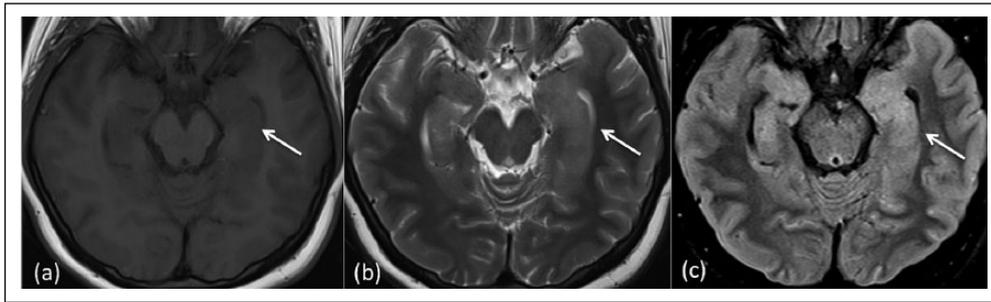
Magnetic resonance imaging scan of the patient at symptom presentation. Axial (a) T1 (b) T2 and (c) FLAIR images demonstrates enlarged left hippocampus which appears mildly hyperintense on T2/FLAIR and hypointense on T1 (white arrows).
